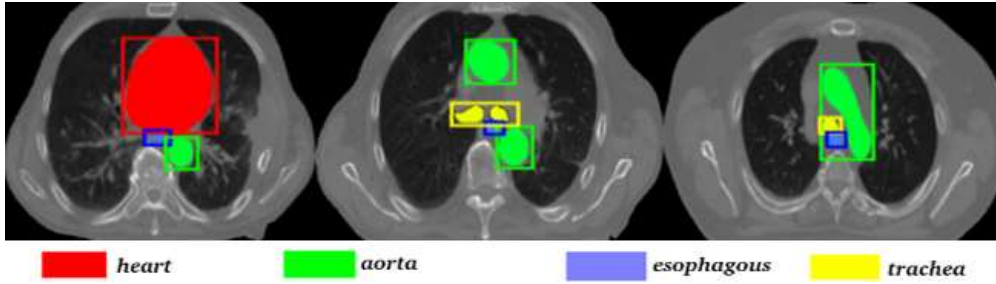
CT images from the SegTHOR dataset with manual segmentation and bounding boxes overlaid on multiple organs (Lambert et al., 2020).
